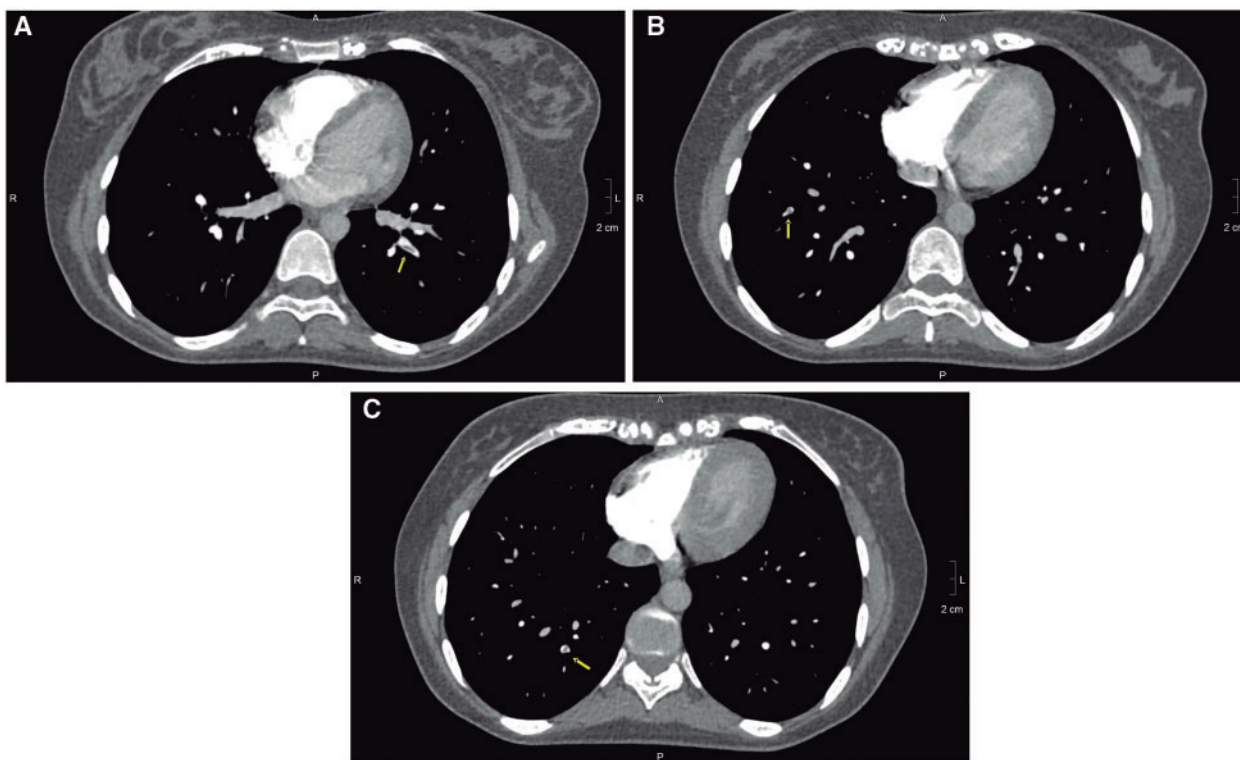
Computed tomography pulmonary angiography. (A) The yellow arrow shows a filling defect in the left lower pulmonary subsegmental artery branch. (B, C) The yellow arrow shows a filling defect in the right lower pulmonary subsegmental artery branch.
